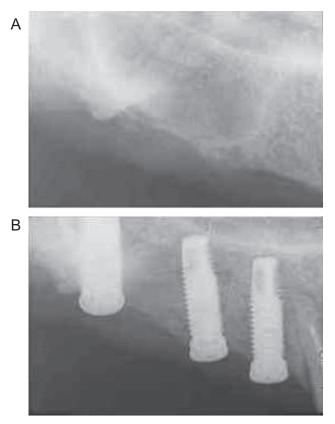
(A) Radiograph of proposed implant site, (B) bone formation at the second surgery.
